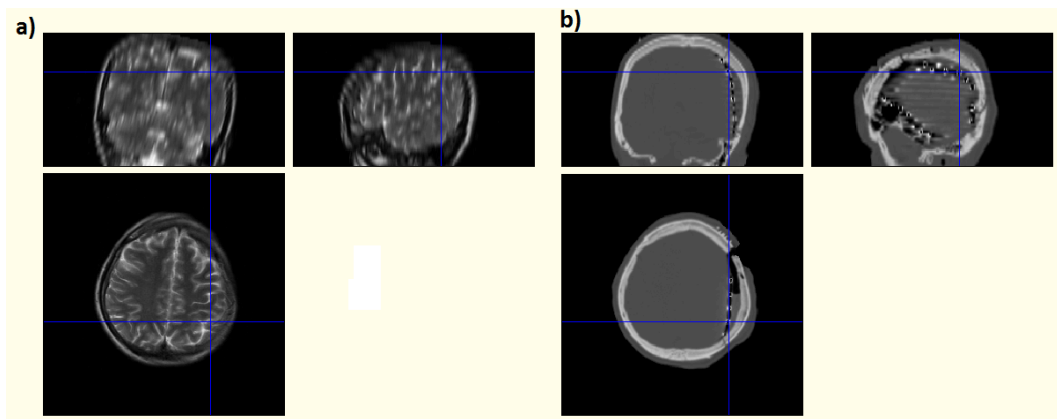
a) MR image, b) White dots in the CT images denote the locations of the subdural electrode contacts
